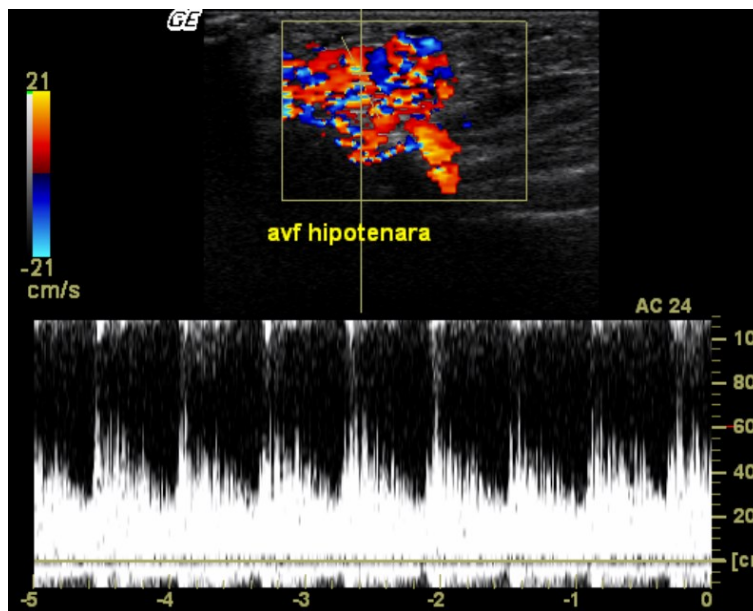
Same patient- Doppler spectrum demonstrating high arterial and venous velocities in AVM
